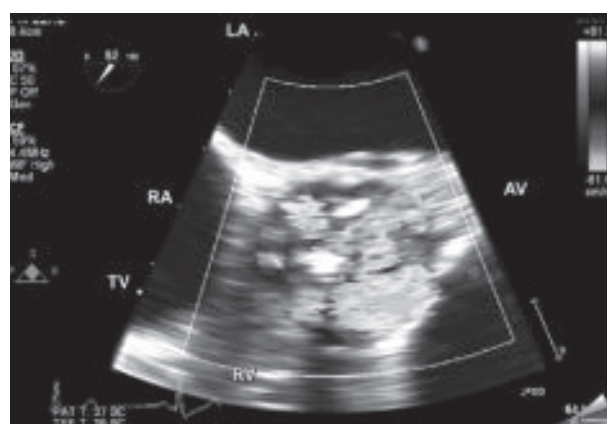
Two- dimensional transesophageal echocardiograms. Show a thickened AV valve.
